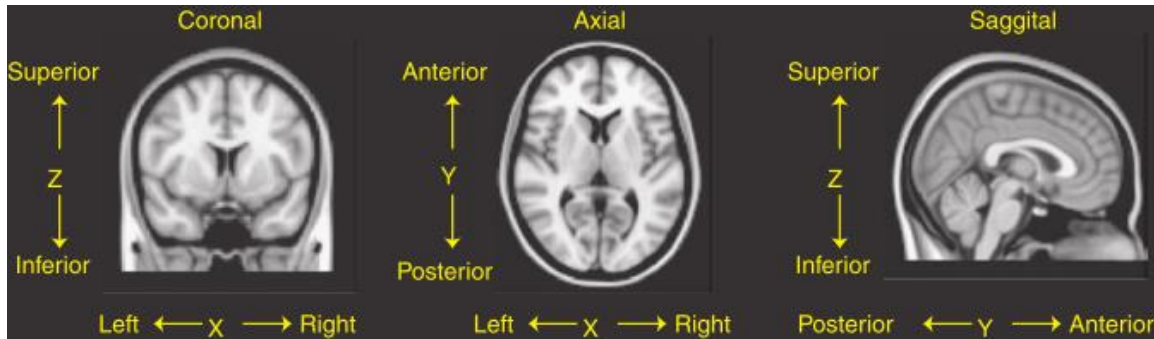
The axial plane, sagittal plane and coronal plane used in the standard coordinate space for MRI; taken from [219]
